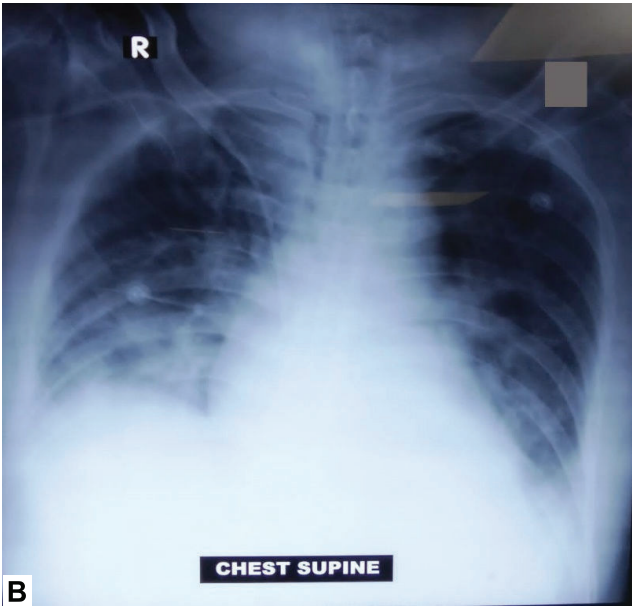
A) Showing negative nasal swab for Respiratory panel (above) and CSF for Neuro-9 PCR panel, B) CXR supine view after respiratory distress showing bilateral (right >left) pulmonary infiltrates, C) &D) showing CT brain Axial and sagittal view respectively showing, tiny hypodense lesion in left frontal lobe and left thalamus generalized cerebral atrophy and ventriculomegaly
